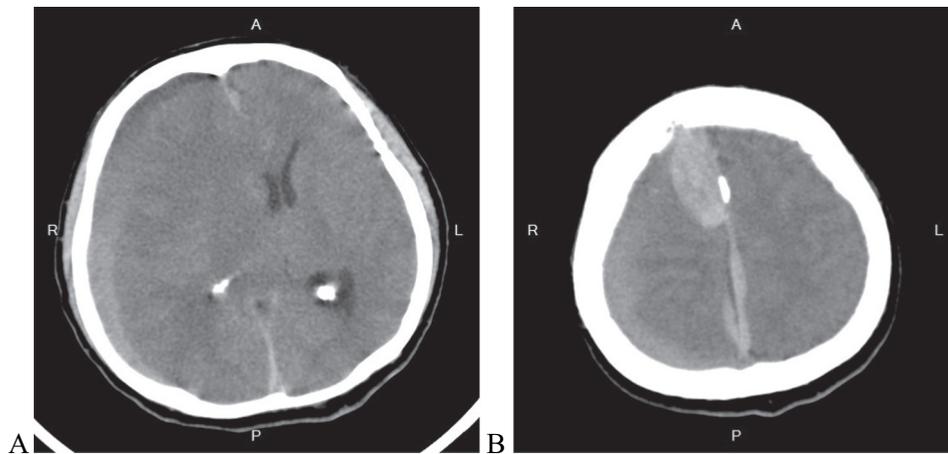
Brain CT showed iso- to hyperdense frontal-temporal-parietal (A) and parafalcine (B) subdural hematoma.
